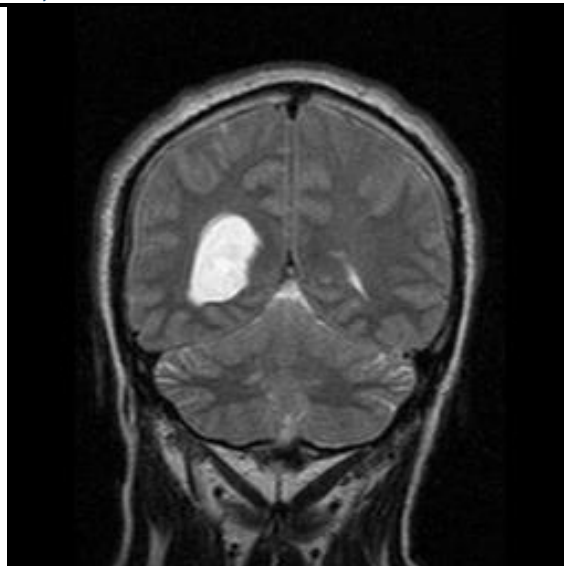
Brain Tumor MRI Image
